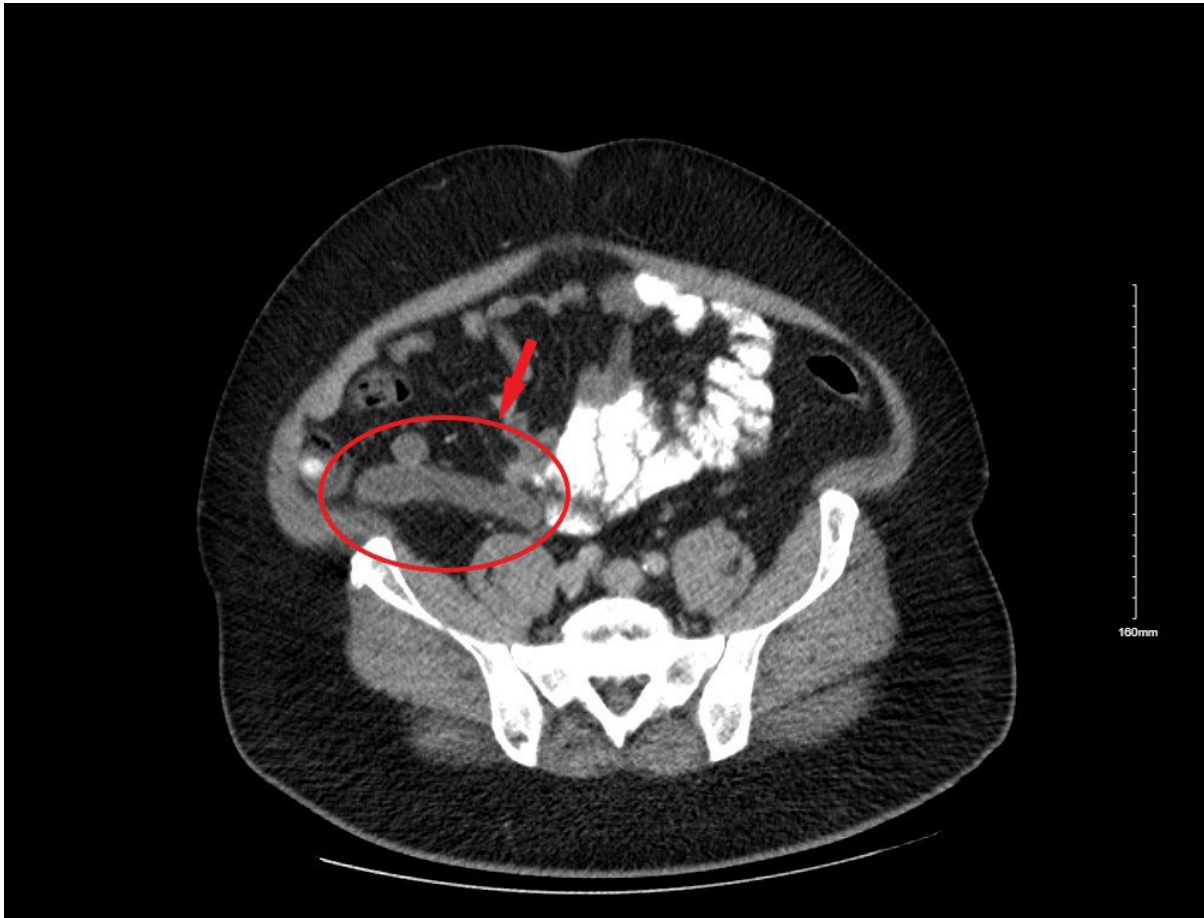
Intravenous and oral contrast-enhanced CT abdomen and pelvis – Axial image
